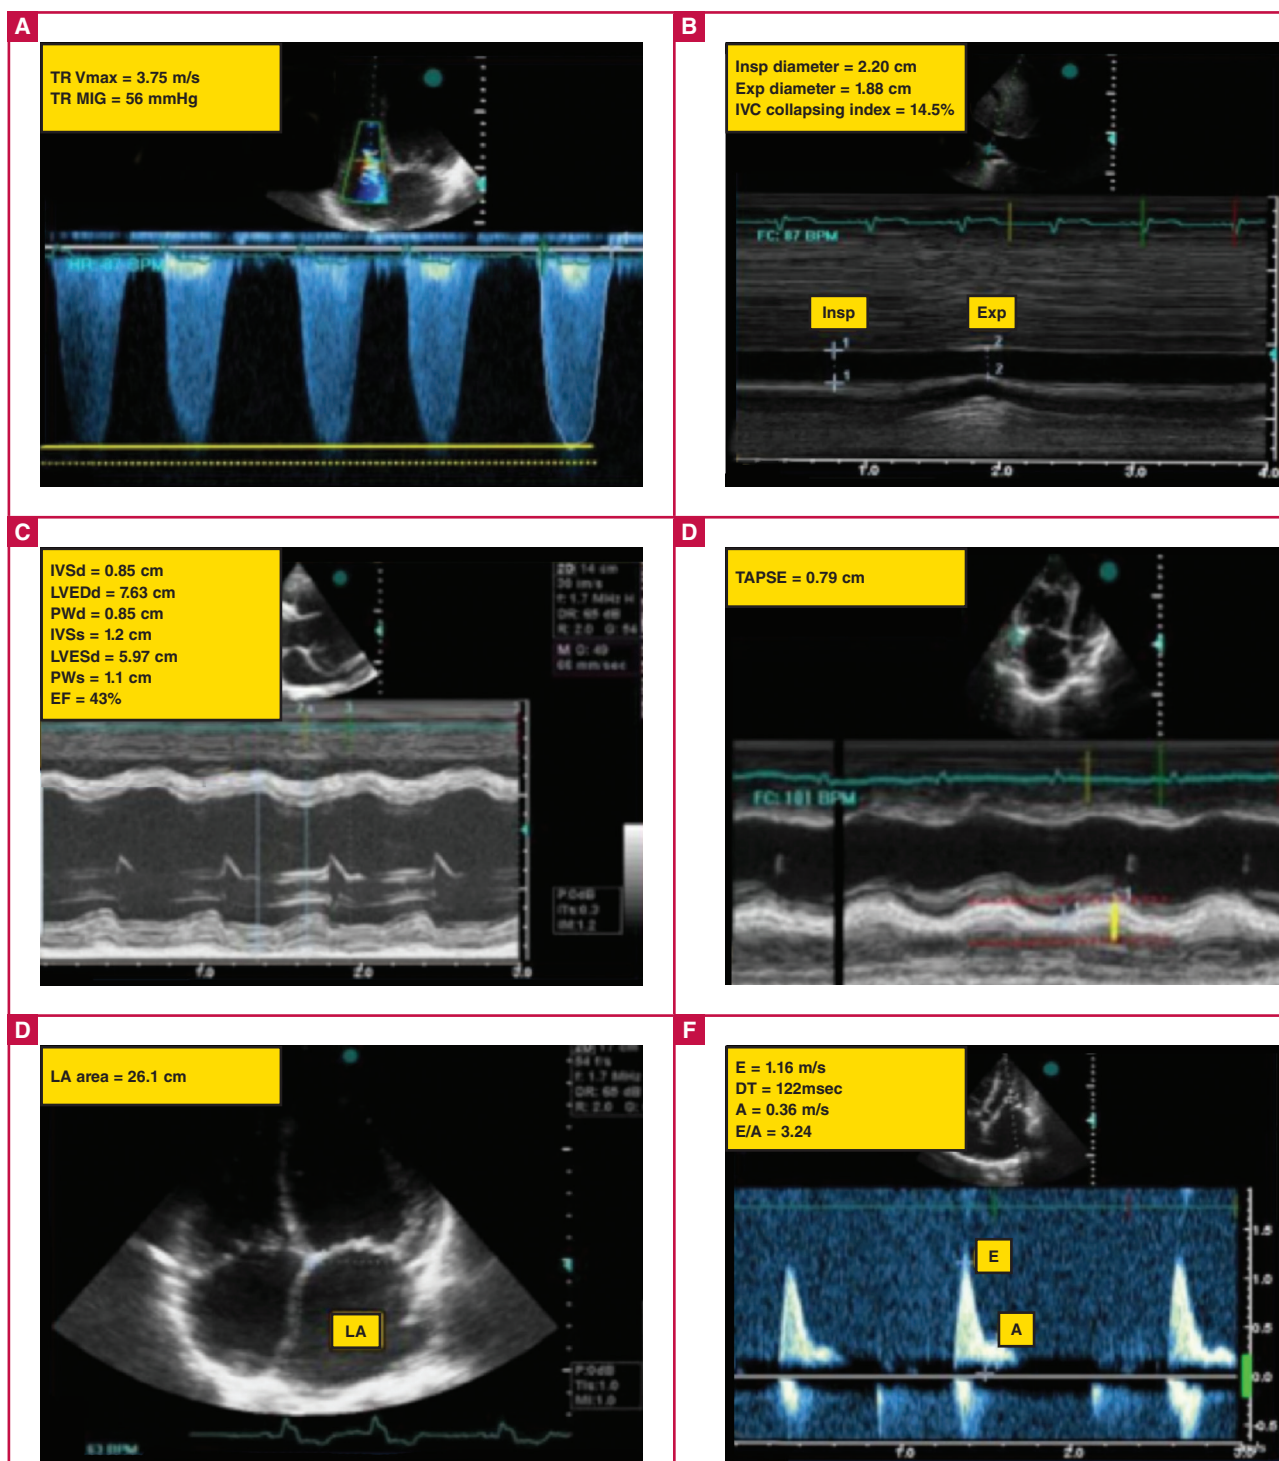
Echocardiographic evaluation in patients with pulmonary hypertension in sub-Saharan Africa. Measurement of pulmonary pressure is based on identification of the tricuspid regurgitant (TR) jet and using continuous-wave Doppler to obtain the maximum instantaneous right ventricular–right atrial gradient, as indicated by the solid yellow line (A). The yellow dotted line indicates measurement of over-gained (shaggy) signals with significant overestimation in the gradient. TR Vmax indicates TR maximal velocity, TR MIG, TR maximal instantaneous gradient. (B) Right atrial pressure is estimated from the inferior vena cava (IVC) calibre and respiratory collapsibility. ins, inspiration, exp, expiration. (C) shows measurements of the ejection fraction using the Teicholz formula; IV(D/S) indicates interventricular septum (diastole/systole), LVED(S)d: left ventricular end-diastolic (systolic) diameter, PWd(s): posterior wall in diastole (systole). (D) indicates the measurement of the tricuspid annular plane systolic excursion (TAPSE) in a patient with right heart failure. (E) A visual assessment of right cardiac cavities in apical four-chamber view showing dilated heart cavities. (F) indicates a restrictive mitral Doppler pattern in the same patient. Modified from thesis 'Predicting pulmonary hypertension and outcomes in patients with left heart disease' <http://hdl.handle.net/11427/16533>.
